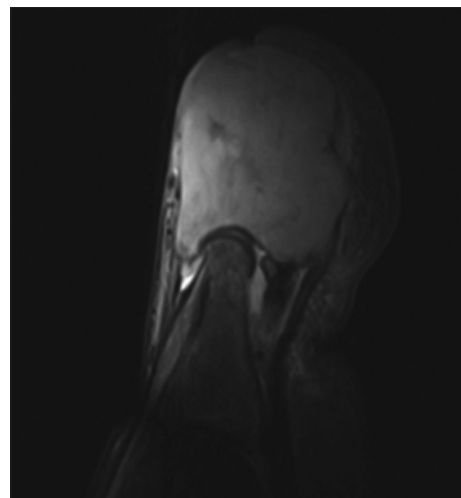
T2-Weighted MRI showed expansile hyperintense lesion involving distal phalanx of great toe with soft tissue extension
